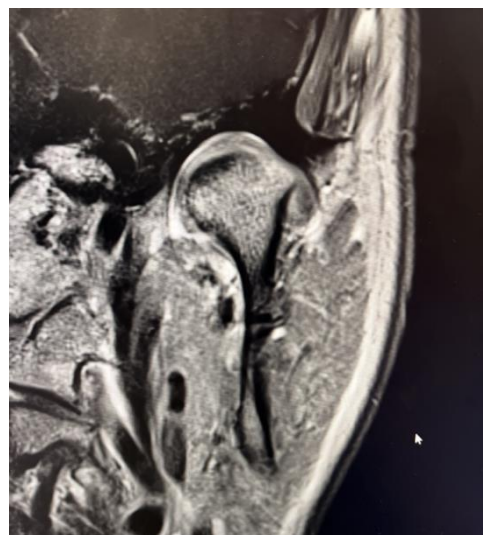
Coronal cut of MRI confirming the disc position in mediolateral direction.
